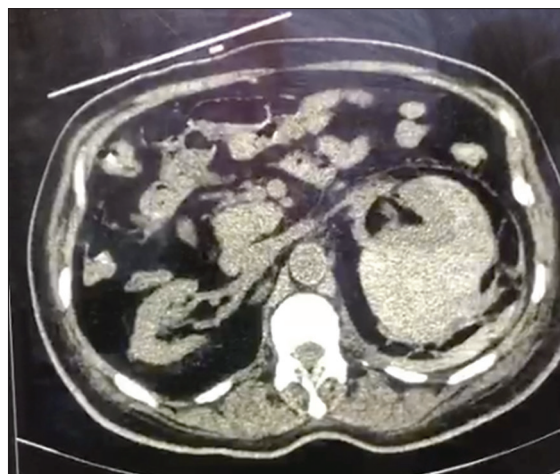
An axial cut of CT abdomen showing the perirenal hematoma
